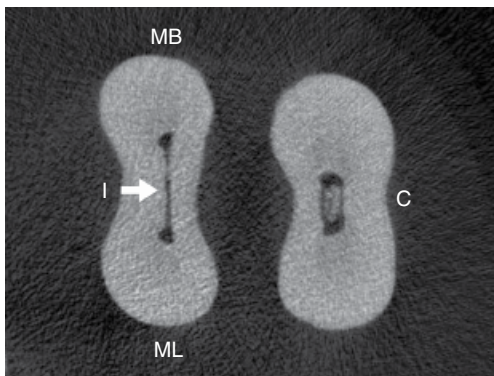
Axial μ -CT view of mesial and distal roots of a first mandibular molar. Isthmus [I] (arrow) connecting mesiobuccal canal [MB] and mesiolingual canals [ML]. Note calcification [C] in distal canal. Courtesy of Dr Vanessa Cabrera Saez, Philadelphia, PA, USA.
